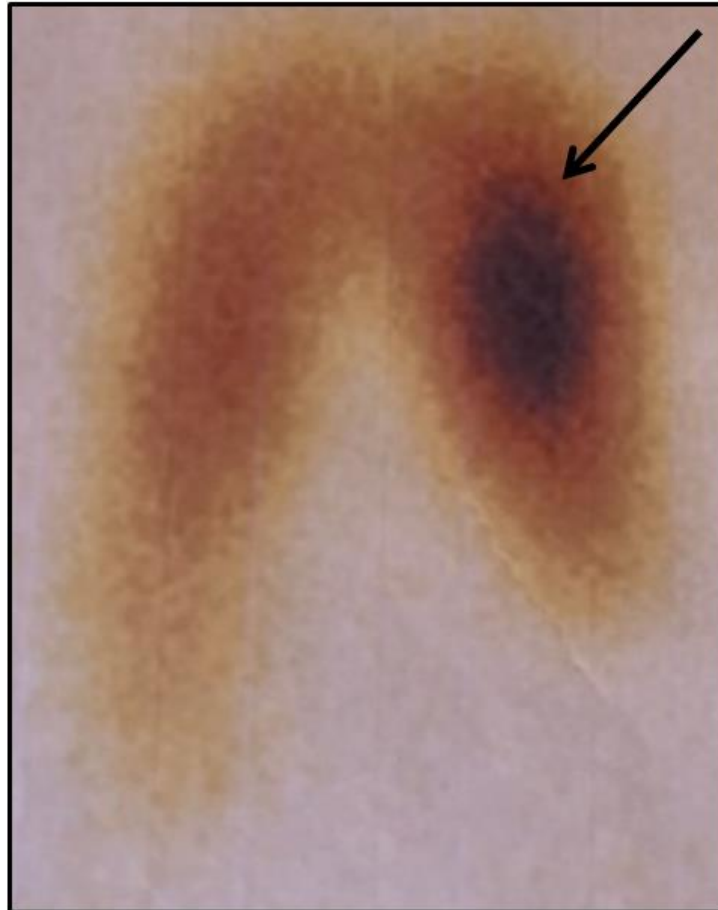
Our patient's scintigraphy: hot nodule
